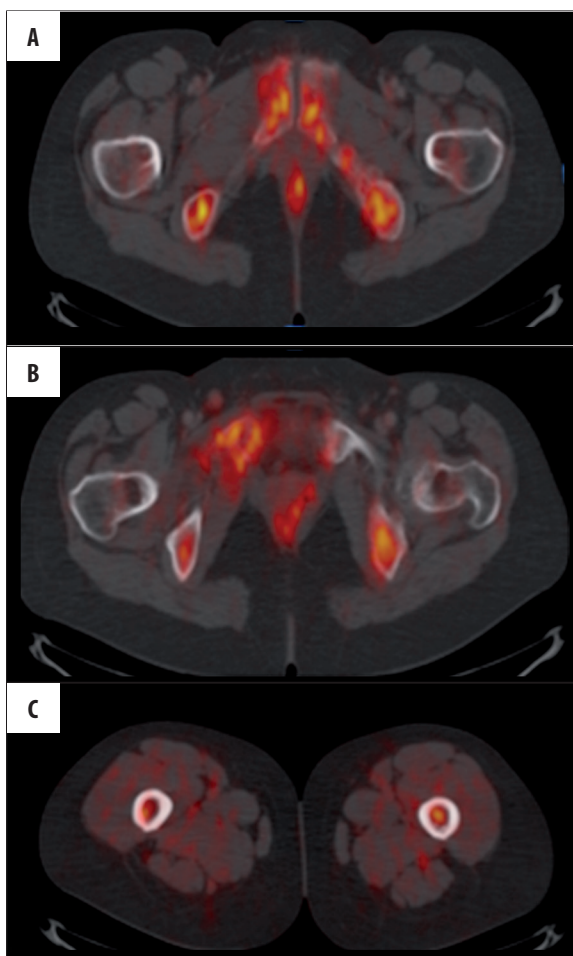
(A, B) Axial PET-CT images showing diffuse abnormal uptake in the bone structures of the pelvis (SUV max from 4 to 7) (C) Axial PET-CT image in which a focus of increased tracer uptake is also detected in the left proximal femur (SUV max 3).
